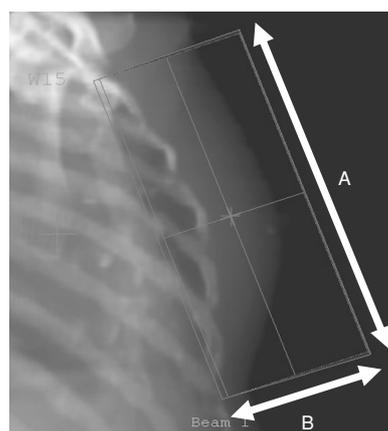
Digitally reconstructed radiography image of the three-dimensional treatment planning device in the radiation field A : long axis length of the radiation field (cm), B : short axis length of the radiation field (cm)
